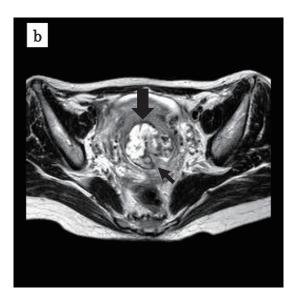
T2-weighted sagittal (a) and axial (b) magnetic resonance images. Magnetic resonance imaging showed a heterogeneous mass (arrow) with both high- and low-signal intensity on the T2-weighted image. The mass was located in the lower uterine cavity and cervical canal and protruded into the cavity from the posterior uterine wall (small arrow).
